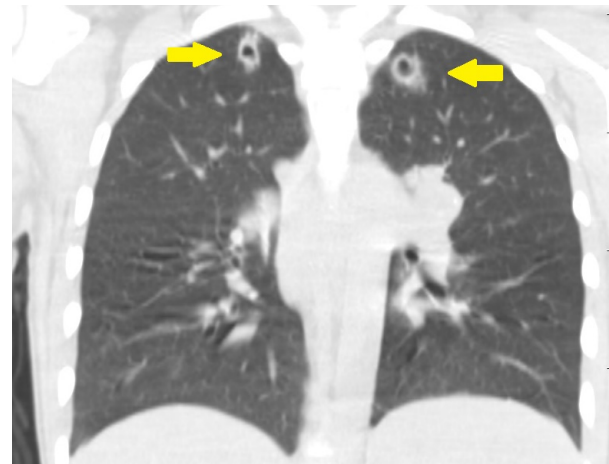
Bilateral apical cavitory lesions – Coronal reformatted images of non enhanced chest CT. Bilateral thick walled cavitory lesions and adjacent ground glass opacity is seen on coronal plane reformatted chest CT images.
